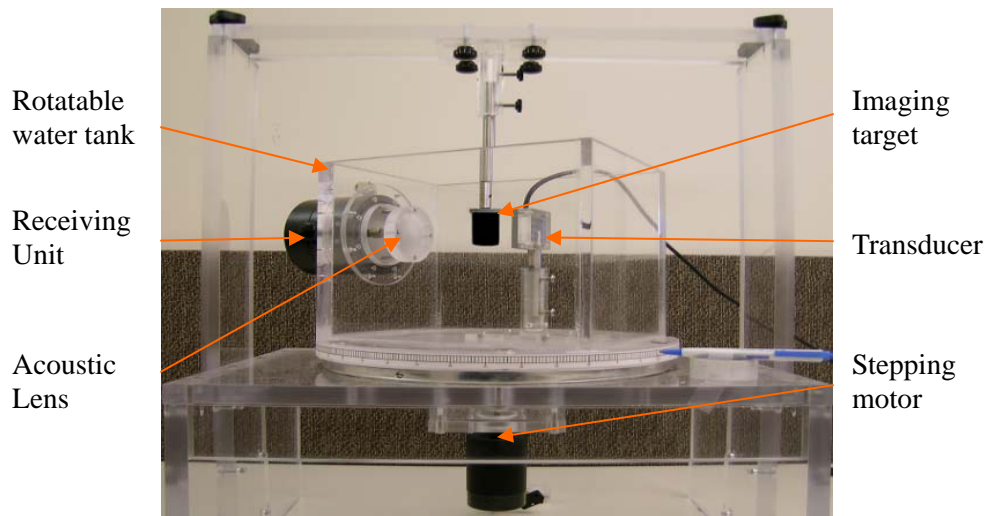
A picture of the new portable ultrasound CT system's configuration.
